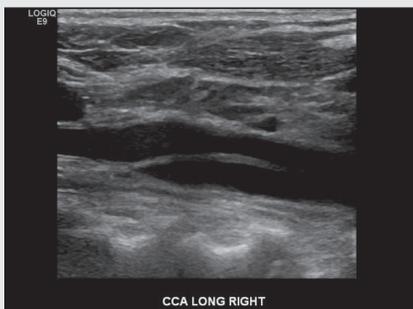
Ultrasound image demonstrating dissection flap in the right common carotid artery (long axis).
